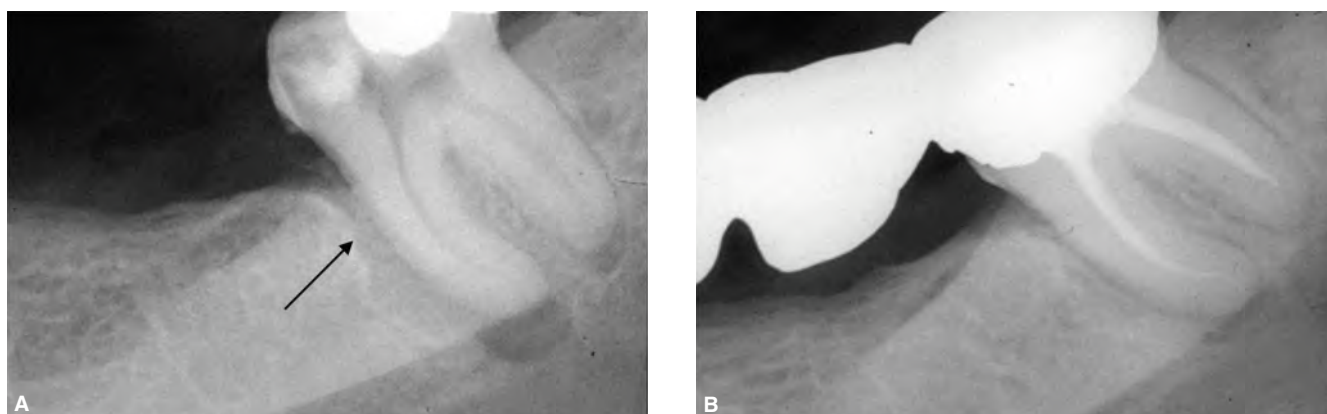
Primary endodontic disease in a mandibular second molar of a 45-year-old male. A. Preoperative radiograph showing evidence of coronal caries and periradicular radiolucencies associated with the affected tooth. Note, localized, narrow and elongated radiolucency alongside the mesial root (arrow). The tooth was symptomatic and pulp sensibility tests were negative. Endodontic treatment was done. B. Two-year follow-up radiograph showing resolution of the periradicular radiolucencies. The patient was comfortable and the tooth has been serving as a distal abutment for a prosthetic reconstruction. (Courtesy of Dr. Borja Zabalegui, Bilbao, Spain.)
